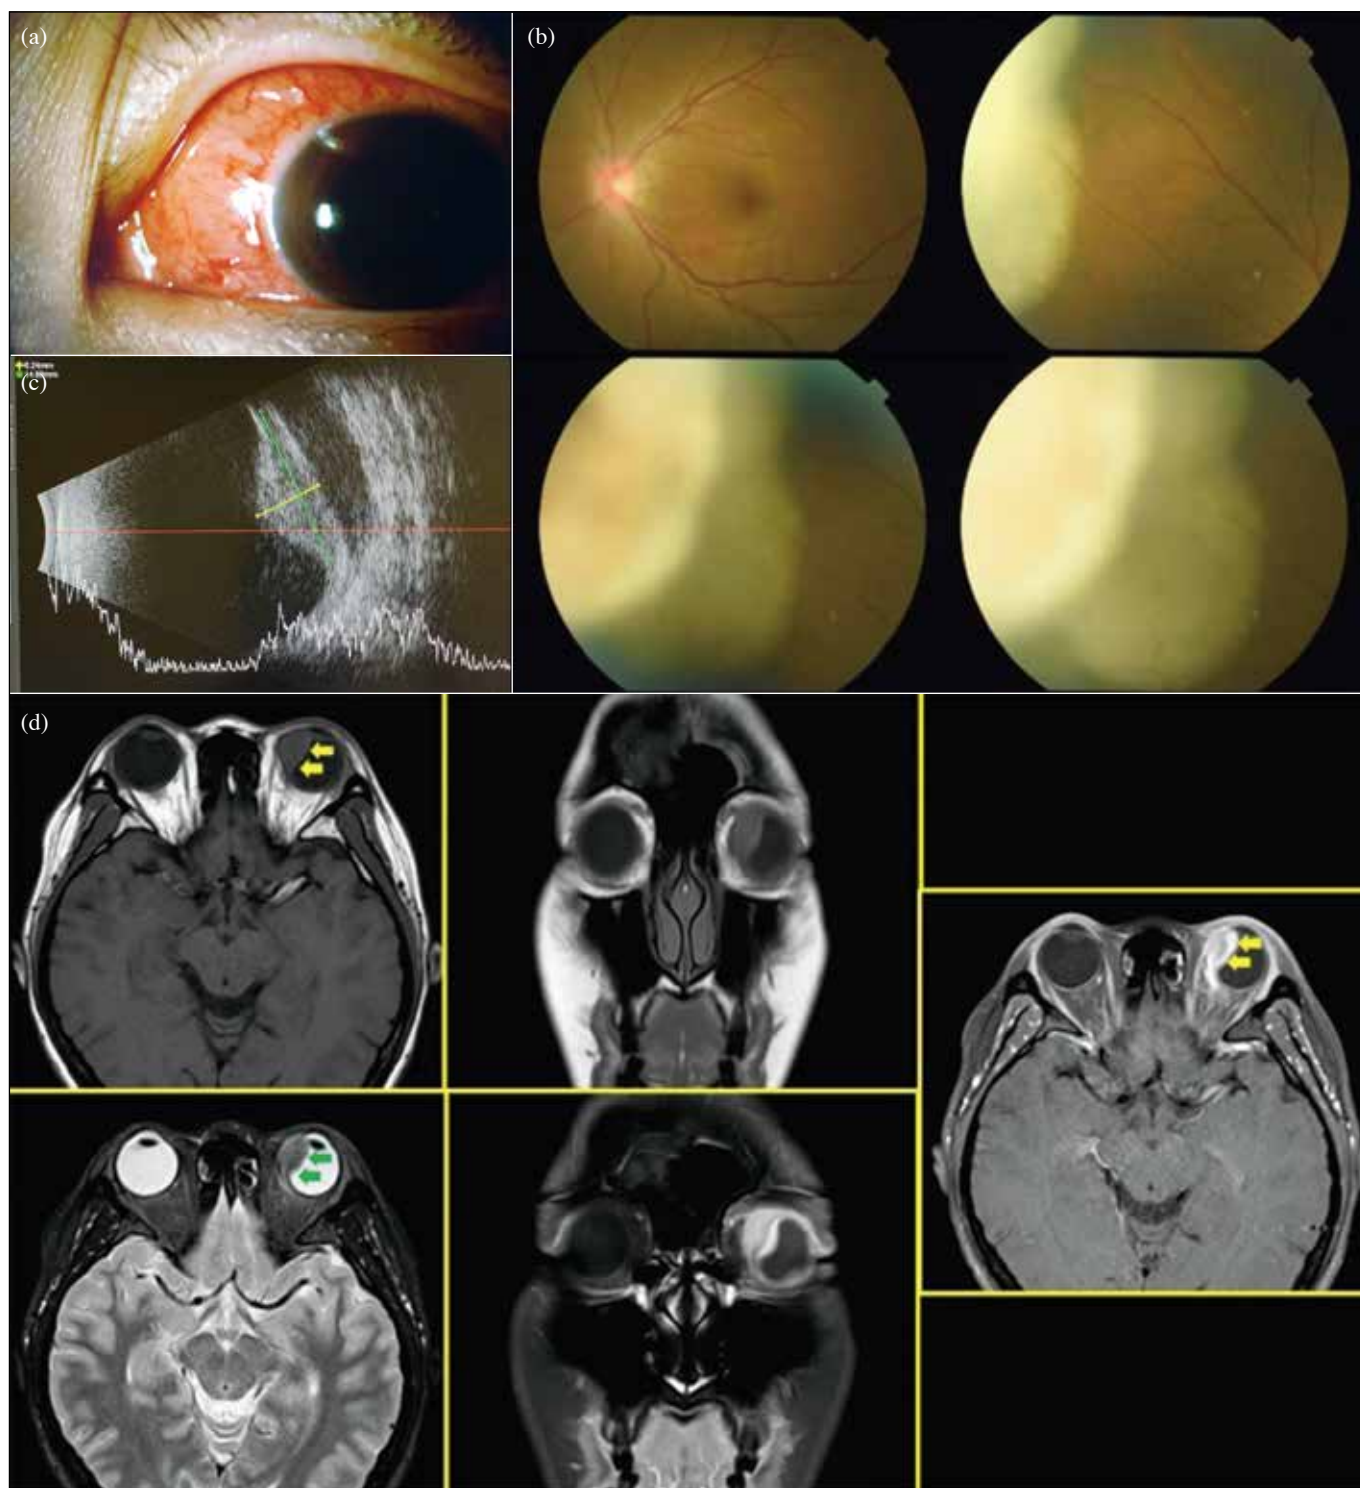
(a) Slit lamp photograph showing left eye sectoral scleritis, (b) dilated fundal examination showing a superonasal choroidal mass, (c) an ultrasound B-scan of the left eye showing a hyperechogenic choroidal mass with choroidal effusion, and (d) a magnetic resonance image of the orbits showing a left intraocular mass and mildly enlarged lacrimal glands bilaterally.
